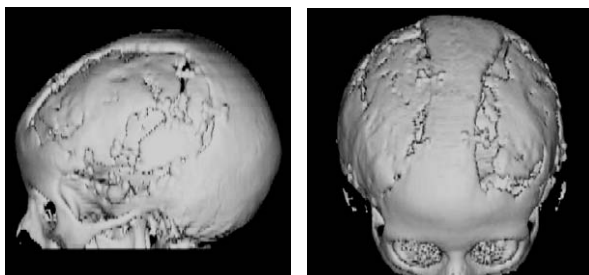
7 year-old girl; 3-D-CT scans: Two views of widespread calvarial bone defects preoperatively.
